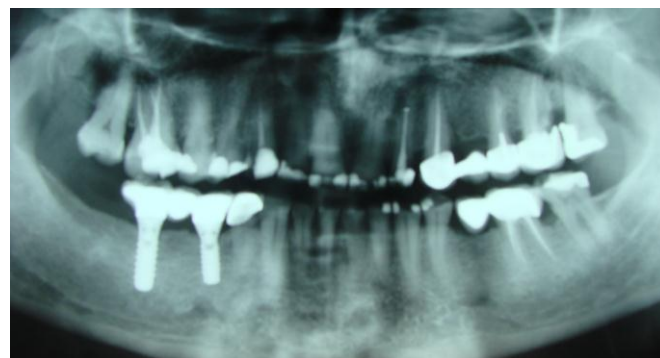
After the loading phase, the implants assessed radiographically.
